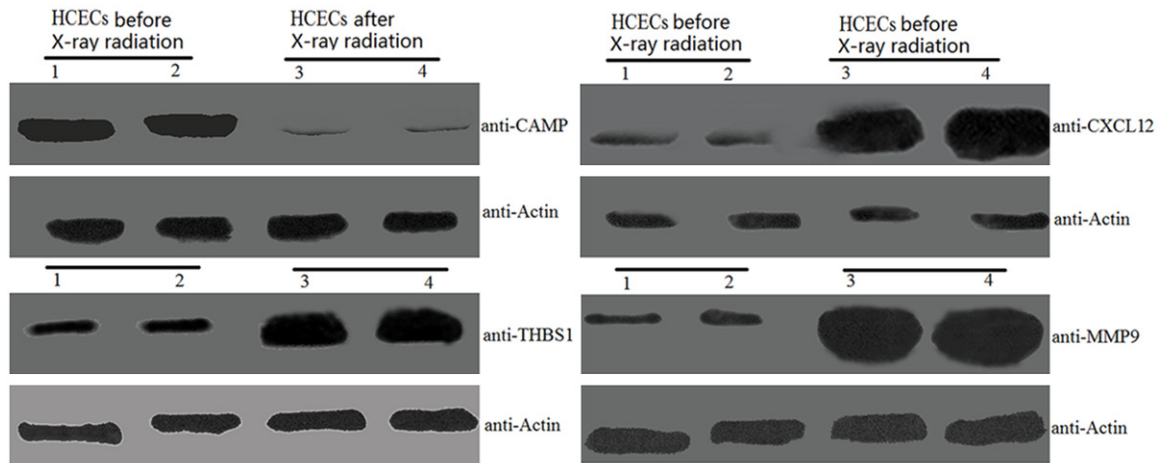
Western blot showing CAMP, THBS1, CXCL12 and MMP9 protein in HCECs before and 4 h after 400 cGy X-ray irradiation. Representative experiments are shown.
